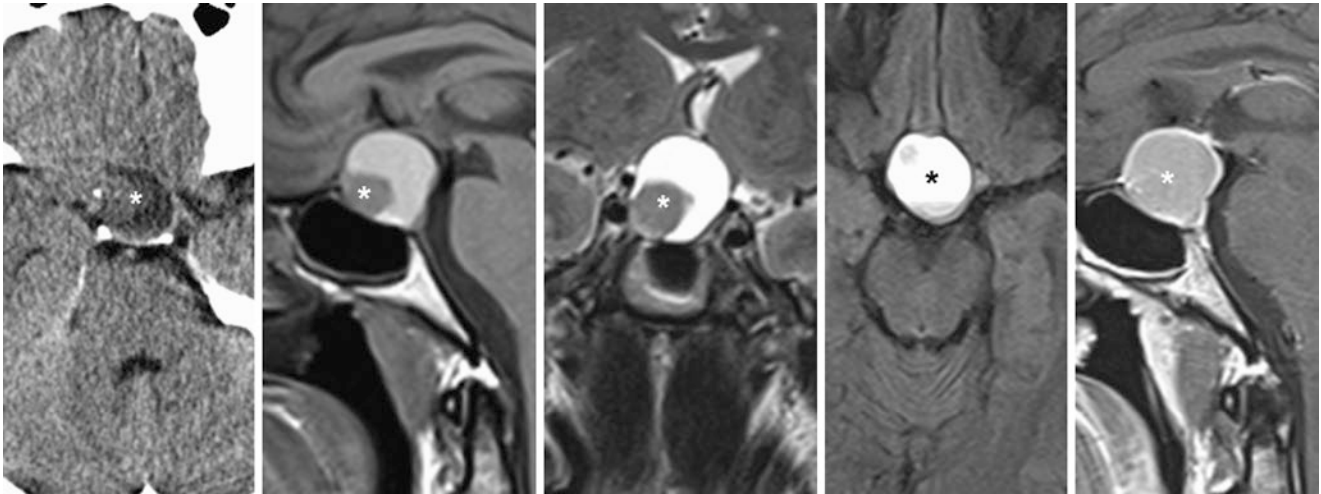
Companion case of hemorrhagic adenoma. A 53-year-old male with visual symptoms underwent NECT (left), which demonstrated a 25×25 mm sellar and suprasellar mass (*). A 1.5 T MRI non-contrast sagittal T1WI (left middle), coronal T2WI (middle), axial
